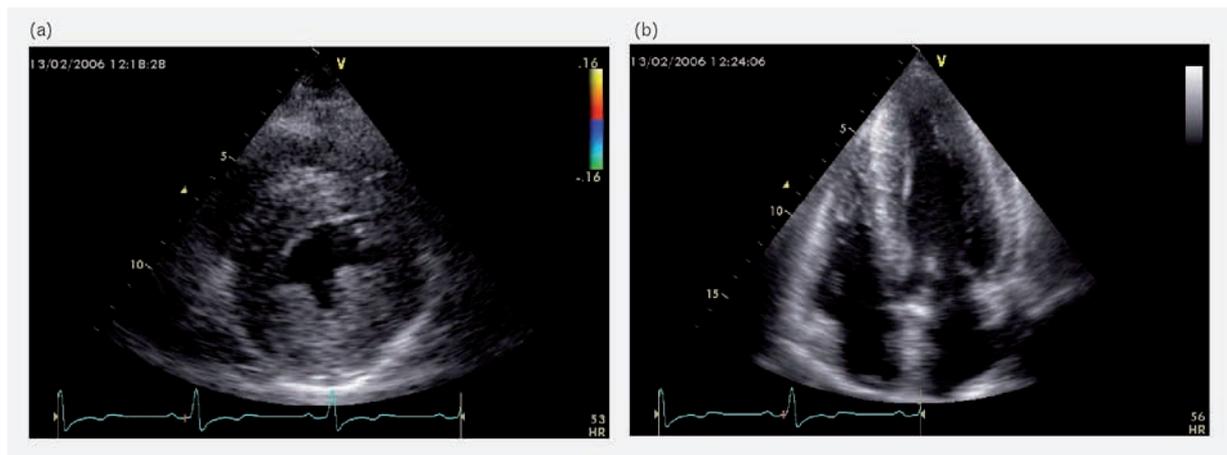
(a) Two-dimensional echocardiogram showing short-axis view of the left ventricle at mitral valve level. There is concentric left ventricular hypertrophy, with enlargement of the papillary muscles. (b) Two-dimensional echocardiogram showing apical four-chamber view. There is hypertrophy of both the left and right ventricles.
